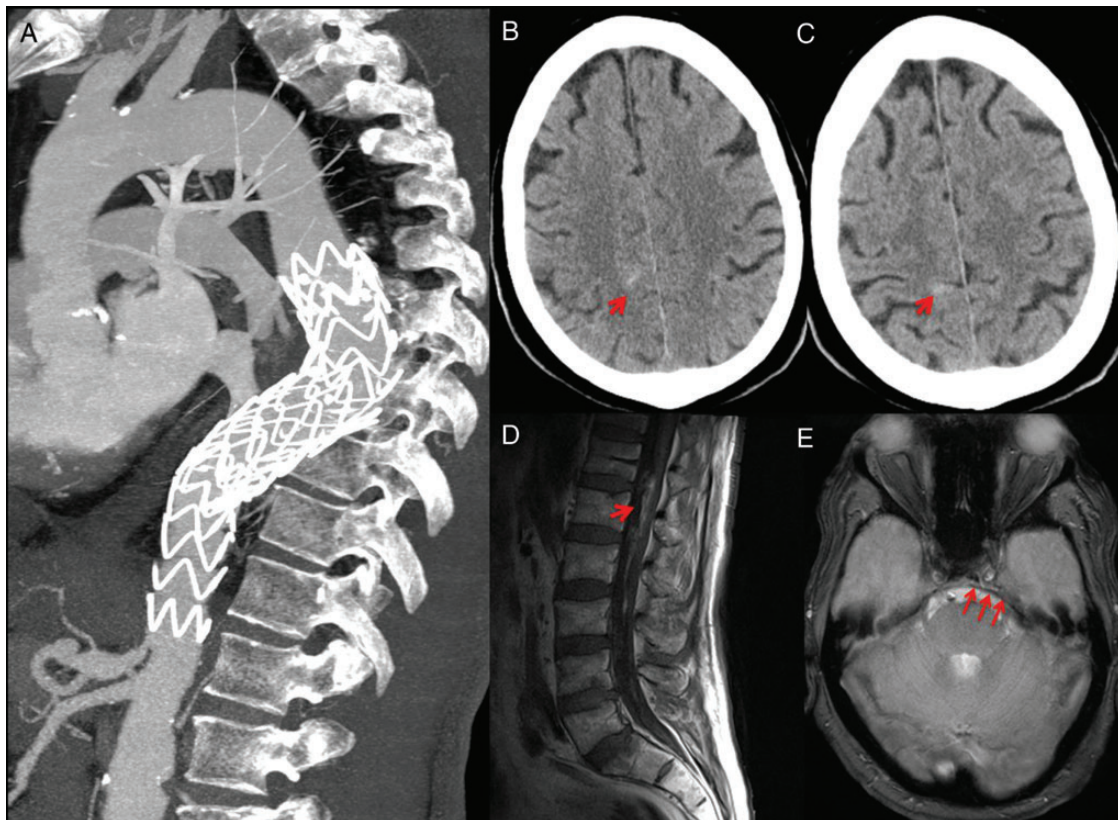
Multislice computed tomography reconstruction (A) showing post-TEVAR final result. Two endovascular grafts extending from the mid-segment of the descending thoracic aorta to the beginning of the abdominal aorta were used. Cerebral computed tomography scan (B and C) revealed parietal sulcus hyperdensity indicating acute subarachnoid haemorrhage. Cerebral and neuroaxial magnetic resonance imaging, T1 sequence (D) depicted hypersignal anterior to the cauda equina, suggesting subacute phase blood (arrow) and T2 gradient echo sequence (E) showed leptomeningeal hyposignal revealing haemosiderin residuals deposits (arrows) suggesting subacute subarachnoid haemorrhage.
